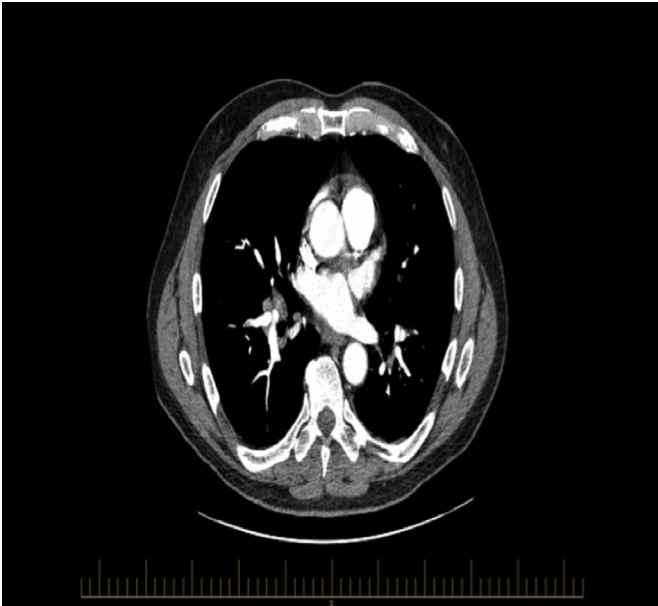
CT chest with contrast showing small filling defects at sub segmental left lower lobe and right lower lobe.
